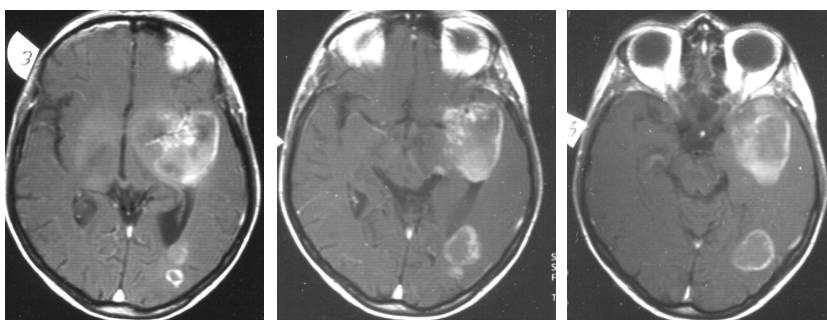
/a. Pretreatment imaging with MRI, -T1, (Gadolinium contrast, 12.06.2002)
